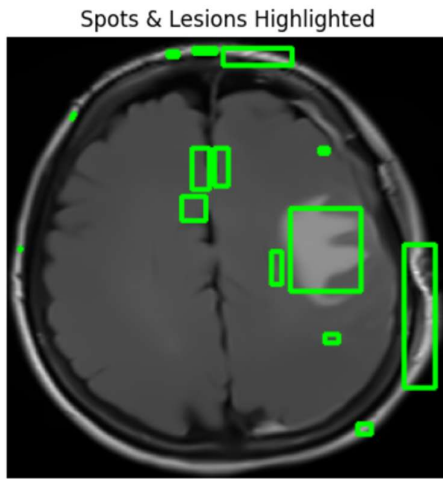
FLAIR MRI Image with Bounding box of MS Lesions
